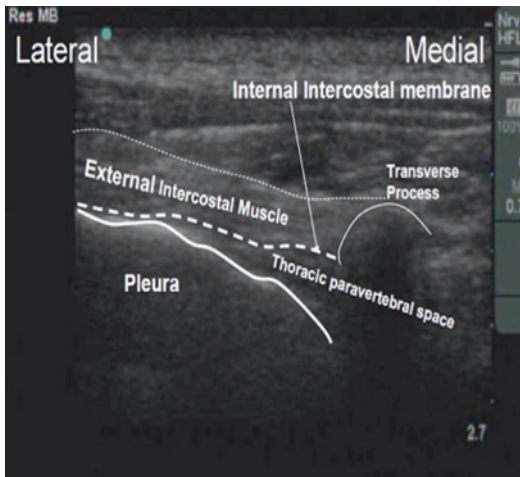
Paravertebral space seen on ultrasound (Courtesy of NYSORA.com)
